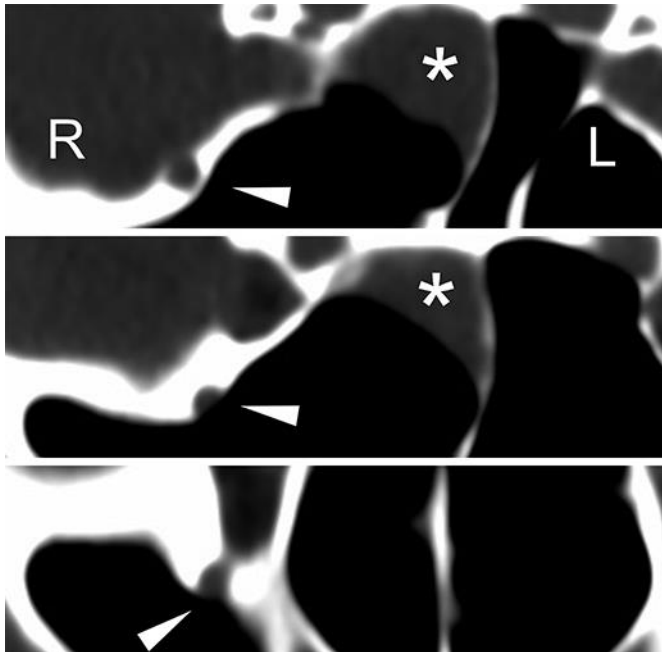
Coronal cross-sectional CT images 7 weeks after onset. These coronal sinus CT images line the dorsal to the ventral side toward the bottom. They reveal a bone defect around the maxillary nerve facing the sphenoid sinus (arrowhead) as well as sphenoid sinusitis with fluid retention (asterisk).
